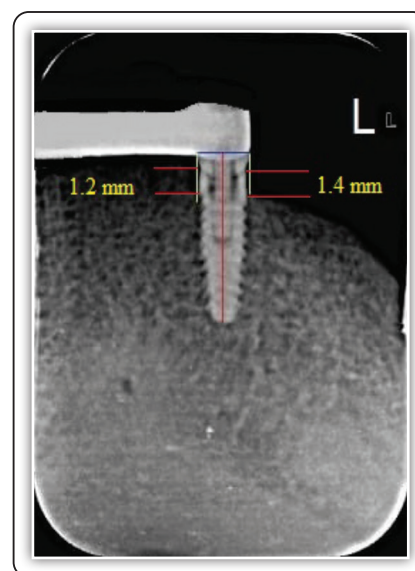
Marginal bone height evaluation using digital peri-apical x-ray.
